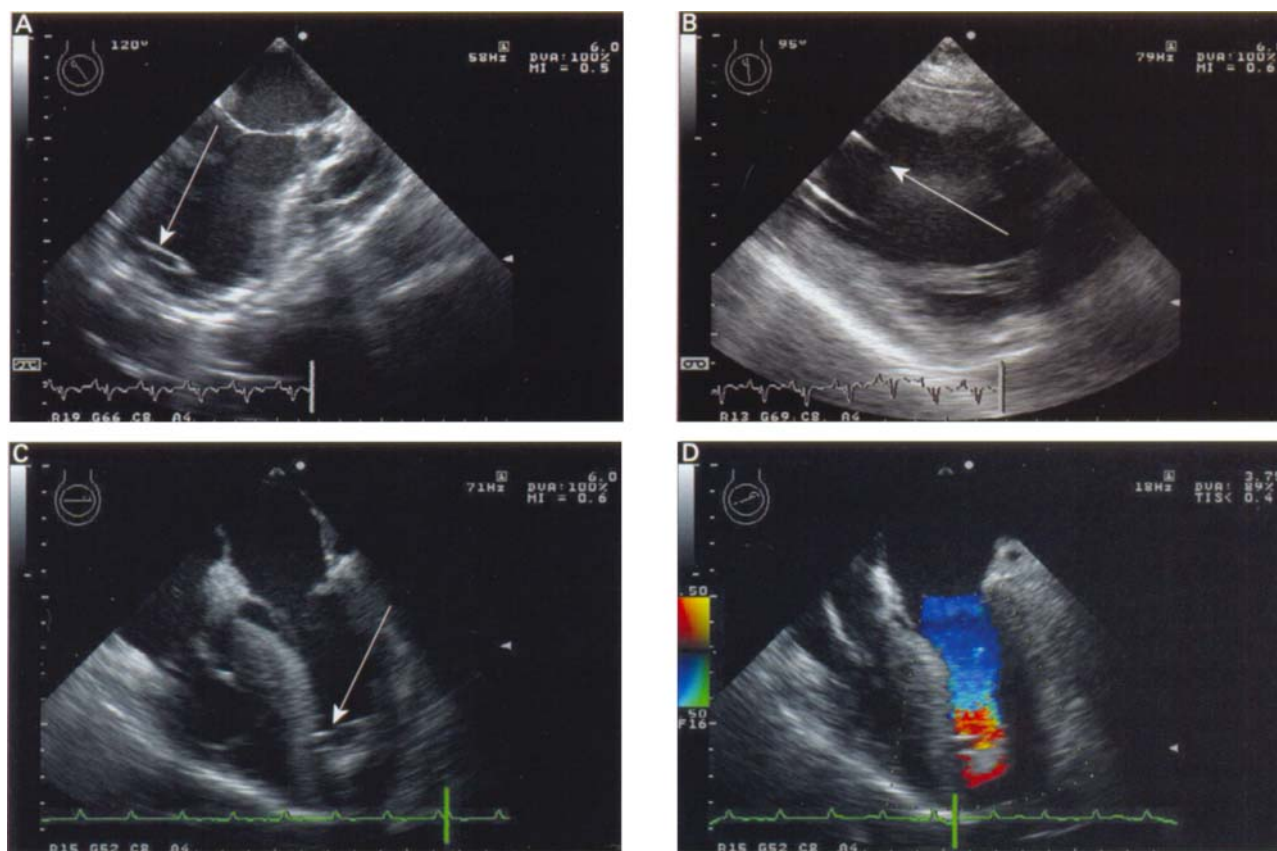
Left ventricular assist device (LVAD) inflow cannula positioned in the left ventricular apex (arrows). Shown are (A) the circular appearing inflow in the mid-oesophageal long-axis view, (B) the centrally orientated cannula in the transgastric two chamber view, and (C) the four chamber view with an unloaded left ventricle with the septum convex to the left ventricle. (D) Colour flow Doppler shows aliasing as blood flow accelerates on entering the cannula.
